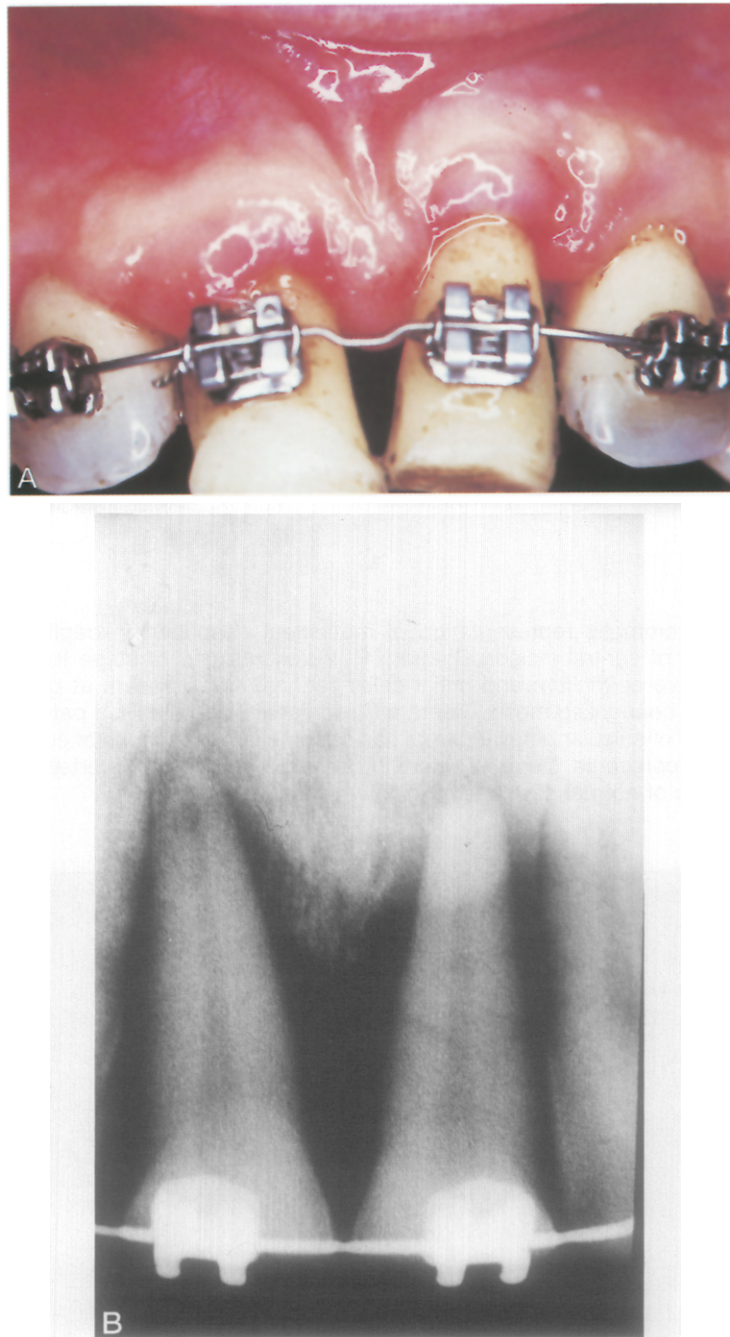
A, Keratinized sulcular epithelium exhibited on maxillary right and left central incisors. Nonkeratinized tissue remains erythematous for 28 to 42 days until keratinization occurs and it assumes keratinized appearance, characteristic of normal surrounding gingiva. B, Radiographically recognized that maxillary central incisors are no longer within confines of alveolus and vertical bone improvement, relative to lateral incisors (periapical radiograph).
